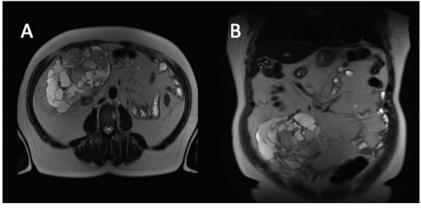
Transverse (A) and coronal (B) sections of a T2-weighted magnetic resonance imaging showing a solid-cystic mass in the right lower quadrant originating from de greater omentum.
